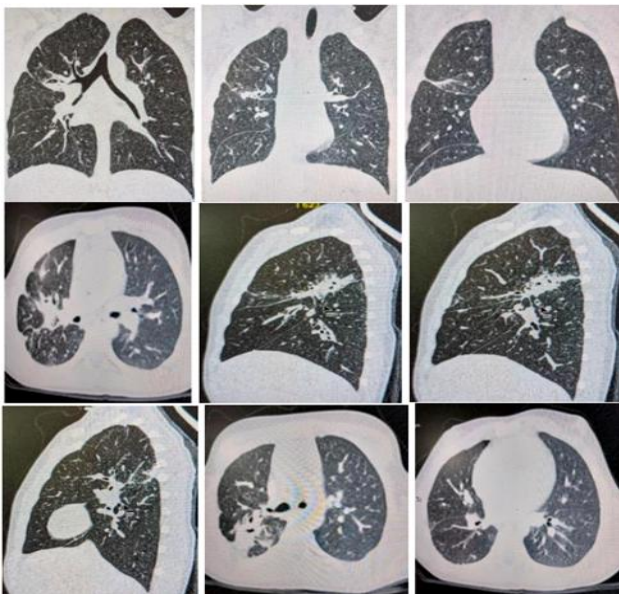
Postoperative CT performed 1, 2 years after the surgery. pulmonary hydatid cyst complicated by spontaneous rupture.
